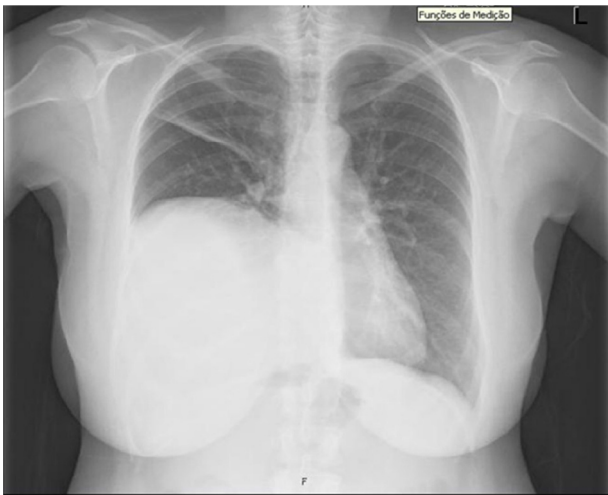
Chest X-ray showing right hemidiaphragm elevation.
